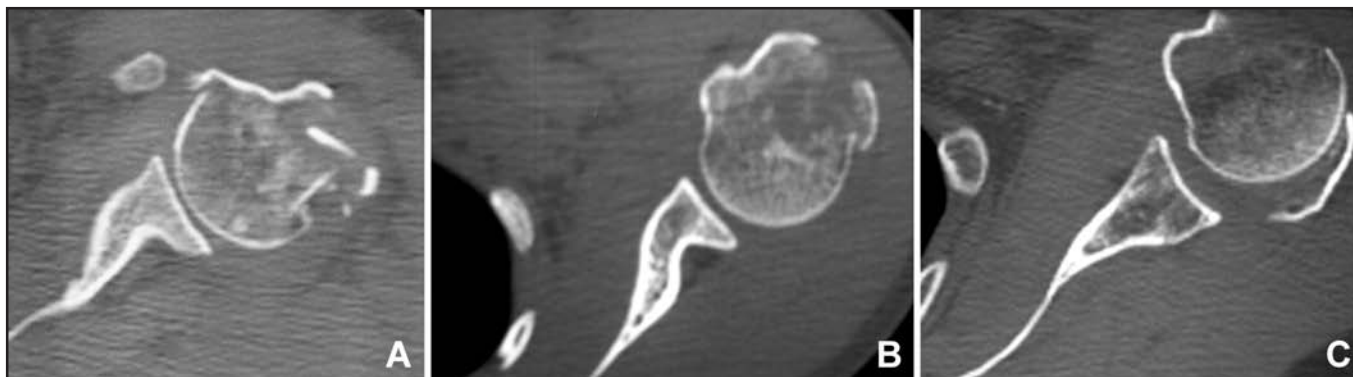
Classification of humeral head orientation. (A) Good, cephaloglenoid angle between 0° and 20° (CT scan, axial view); (B) Sufficient, with cephaloglenoid angle between 20° and 45° (CT scan, axial view); (C) Deficient, cephaloglenoid angle $>45^\circ$ (CT scan, axial view).
